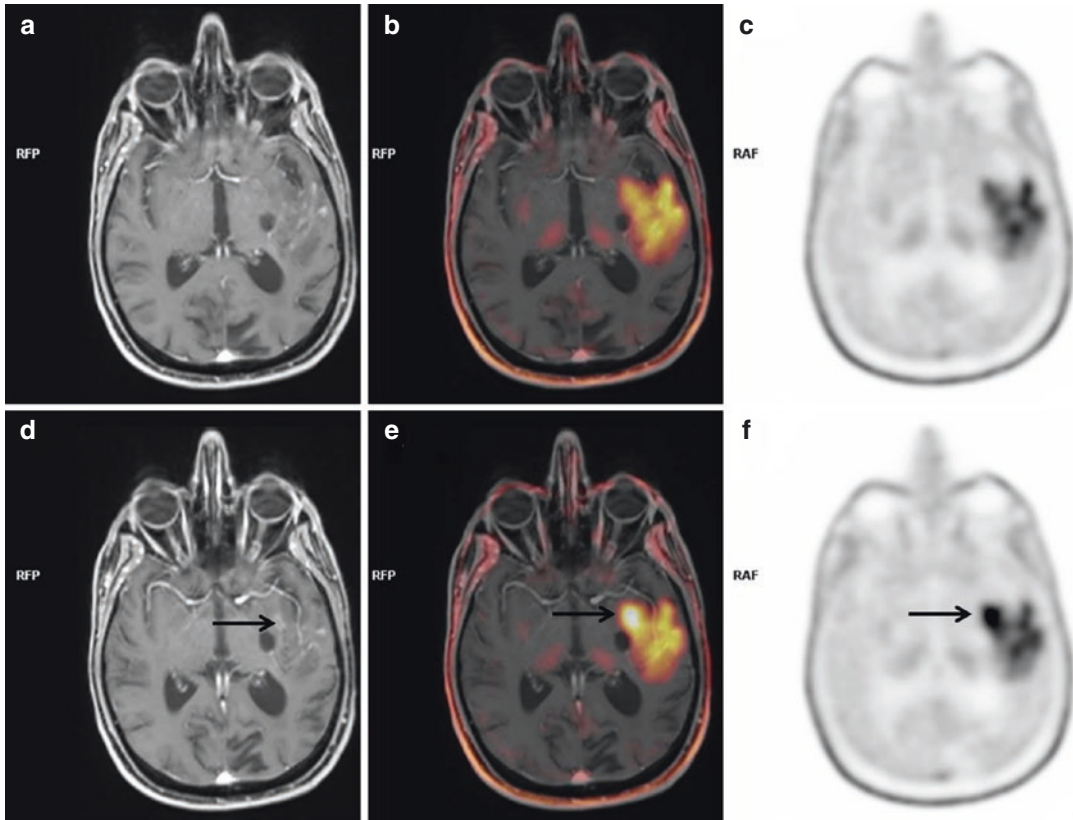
Axial MRI (a, d), fused ^{18}F -FET PET/MRI (b, e) and ^{18}F -FET PET (c, f) images in a 58 y.o. male patient with a recurrent left temporal high-grade glioma post-radiochemotherapy, before (a–c) and after (d–f) antiangiogenic therapy.
